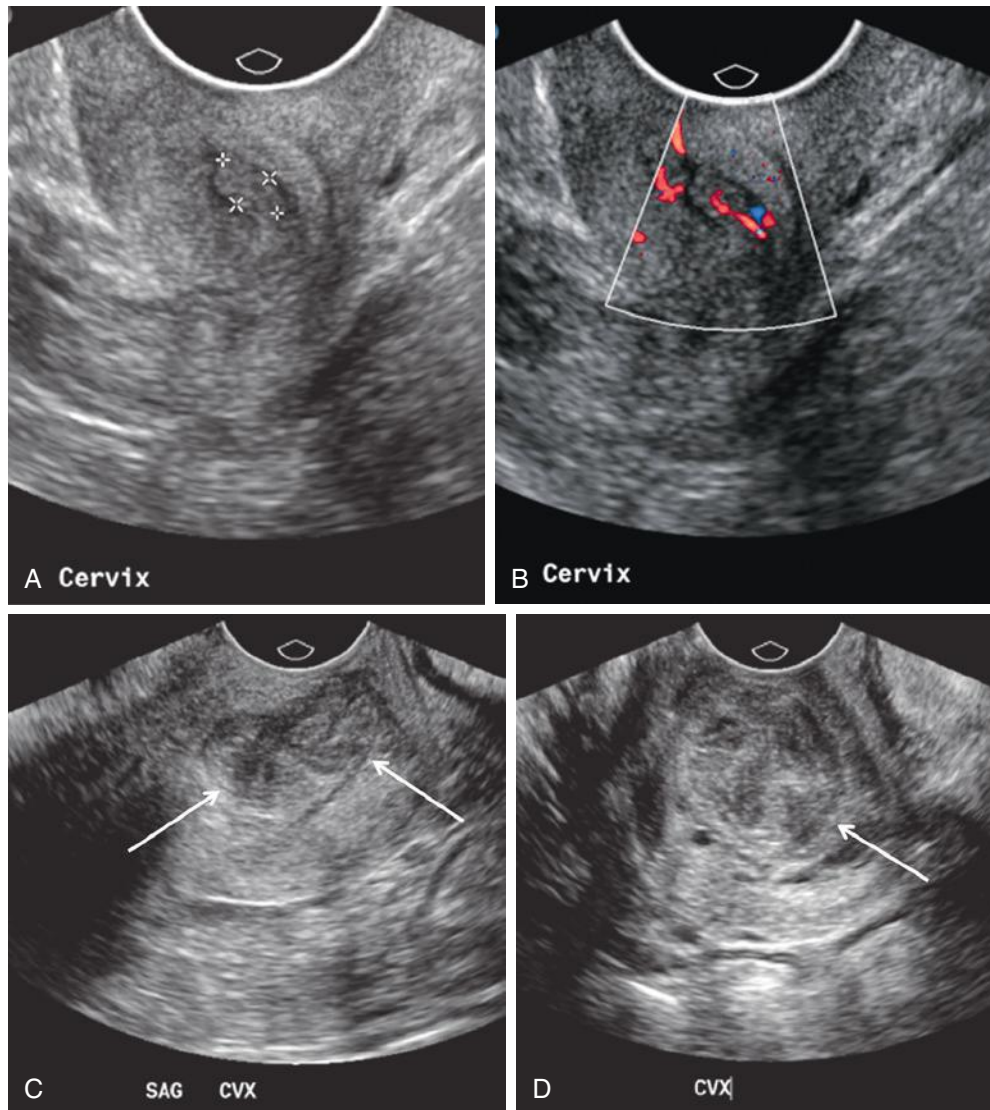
Endocervical polyps. A, Transvaginal gray-scale image of the cervix demonstrates a small mass (*calipers*) within the endocervical canal. The differential diagnosis includes blood clot, mucous plug, and debris as well as endocervical polyp. B, Corresponding color Doppler image reveals internal vascularity and a feeding vessel, confirming that this is a soft tissue mass, most likely an endocervical polyp rather than blood clot or mucous plug. C and D, Sagittal and transverse transvaginal gray-scale images of the cervix from another patient with a large, slightly heterogeneous endocervical polyp (*arrows*) distending the endocervical canal.
